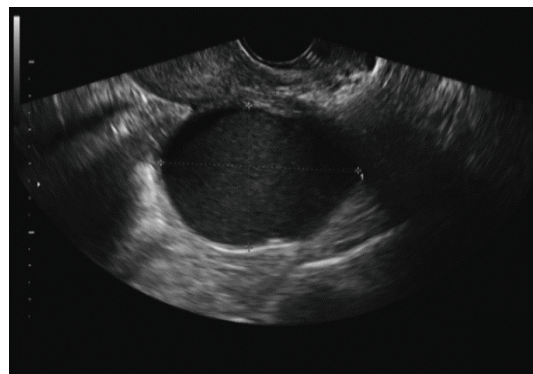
Transvaginal sonogram of an adnexal mass using IOTA-SRs diagnosis of borderline tumors. Postoperative pathology suggested malignant transformation
